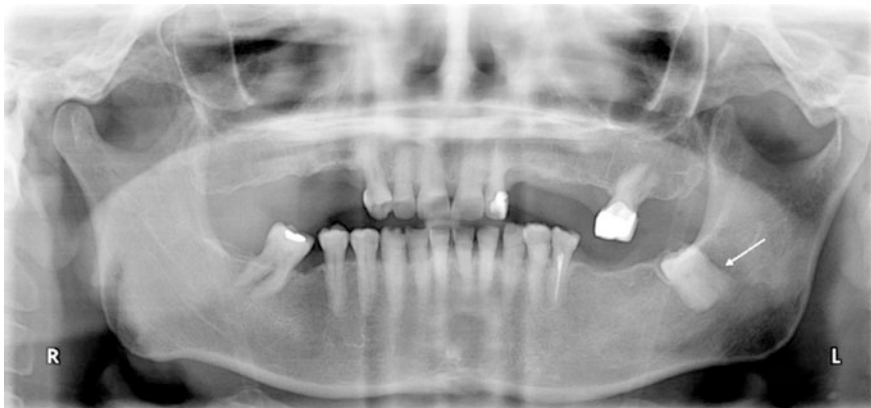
Preoperative orthopantomography: 3.8 is impacted and dysodontiasic (*arrow*); restorative treatment in tooth 4.7, partially edentulous dental arches
